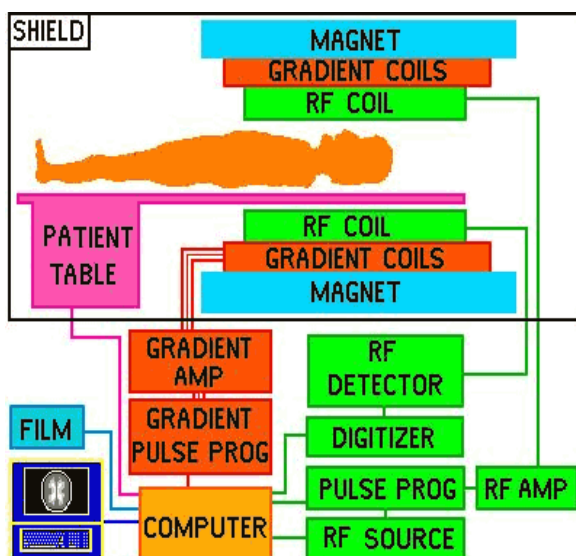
The constructional overview of MRI Machines
